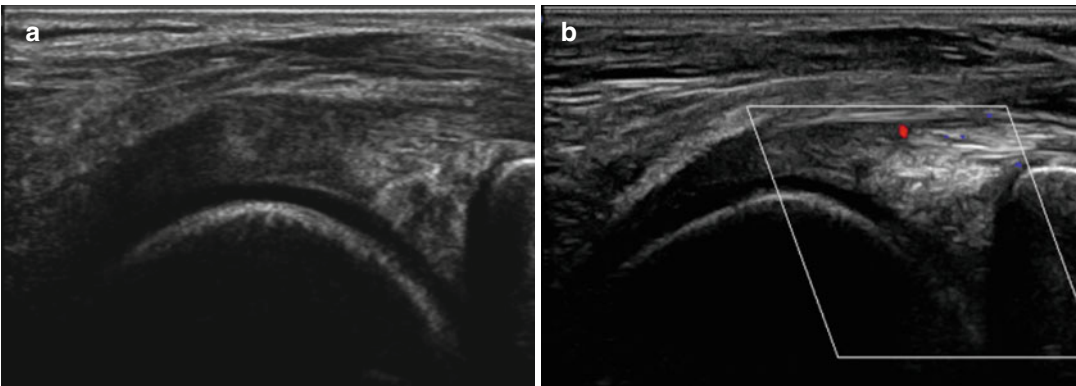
(a) Posteromedial meniscus (b) Vascular Doppler technology
